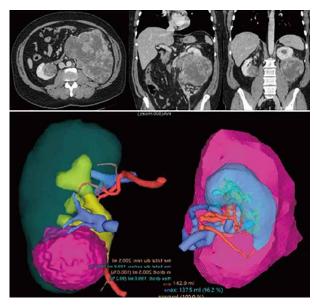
Preoperative CT scan and 3D models of FR-BOD-P*-2511 patient treated for bilateral kidney lesions (A: right kidney; B: left kidney)
